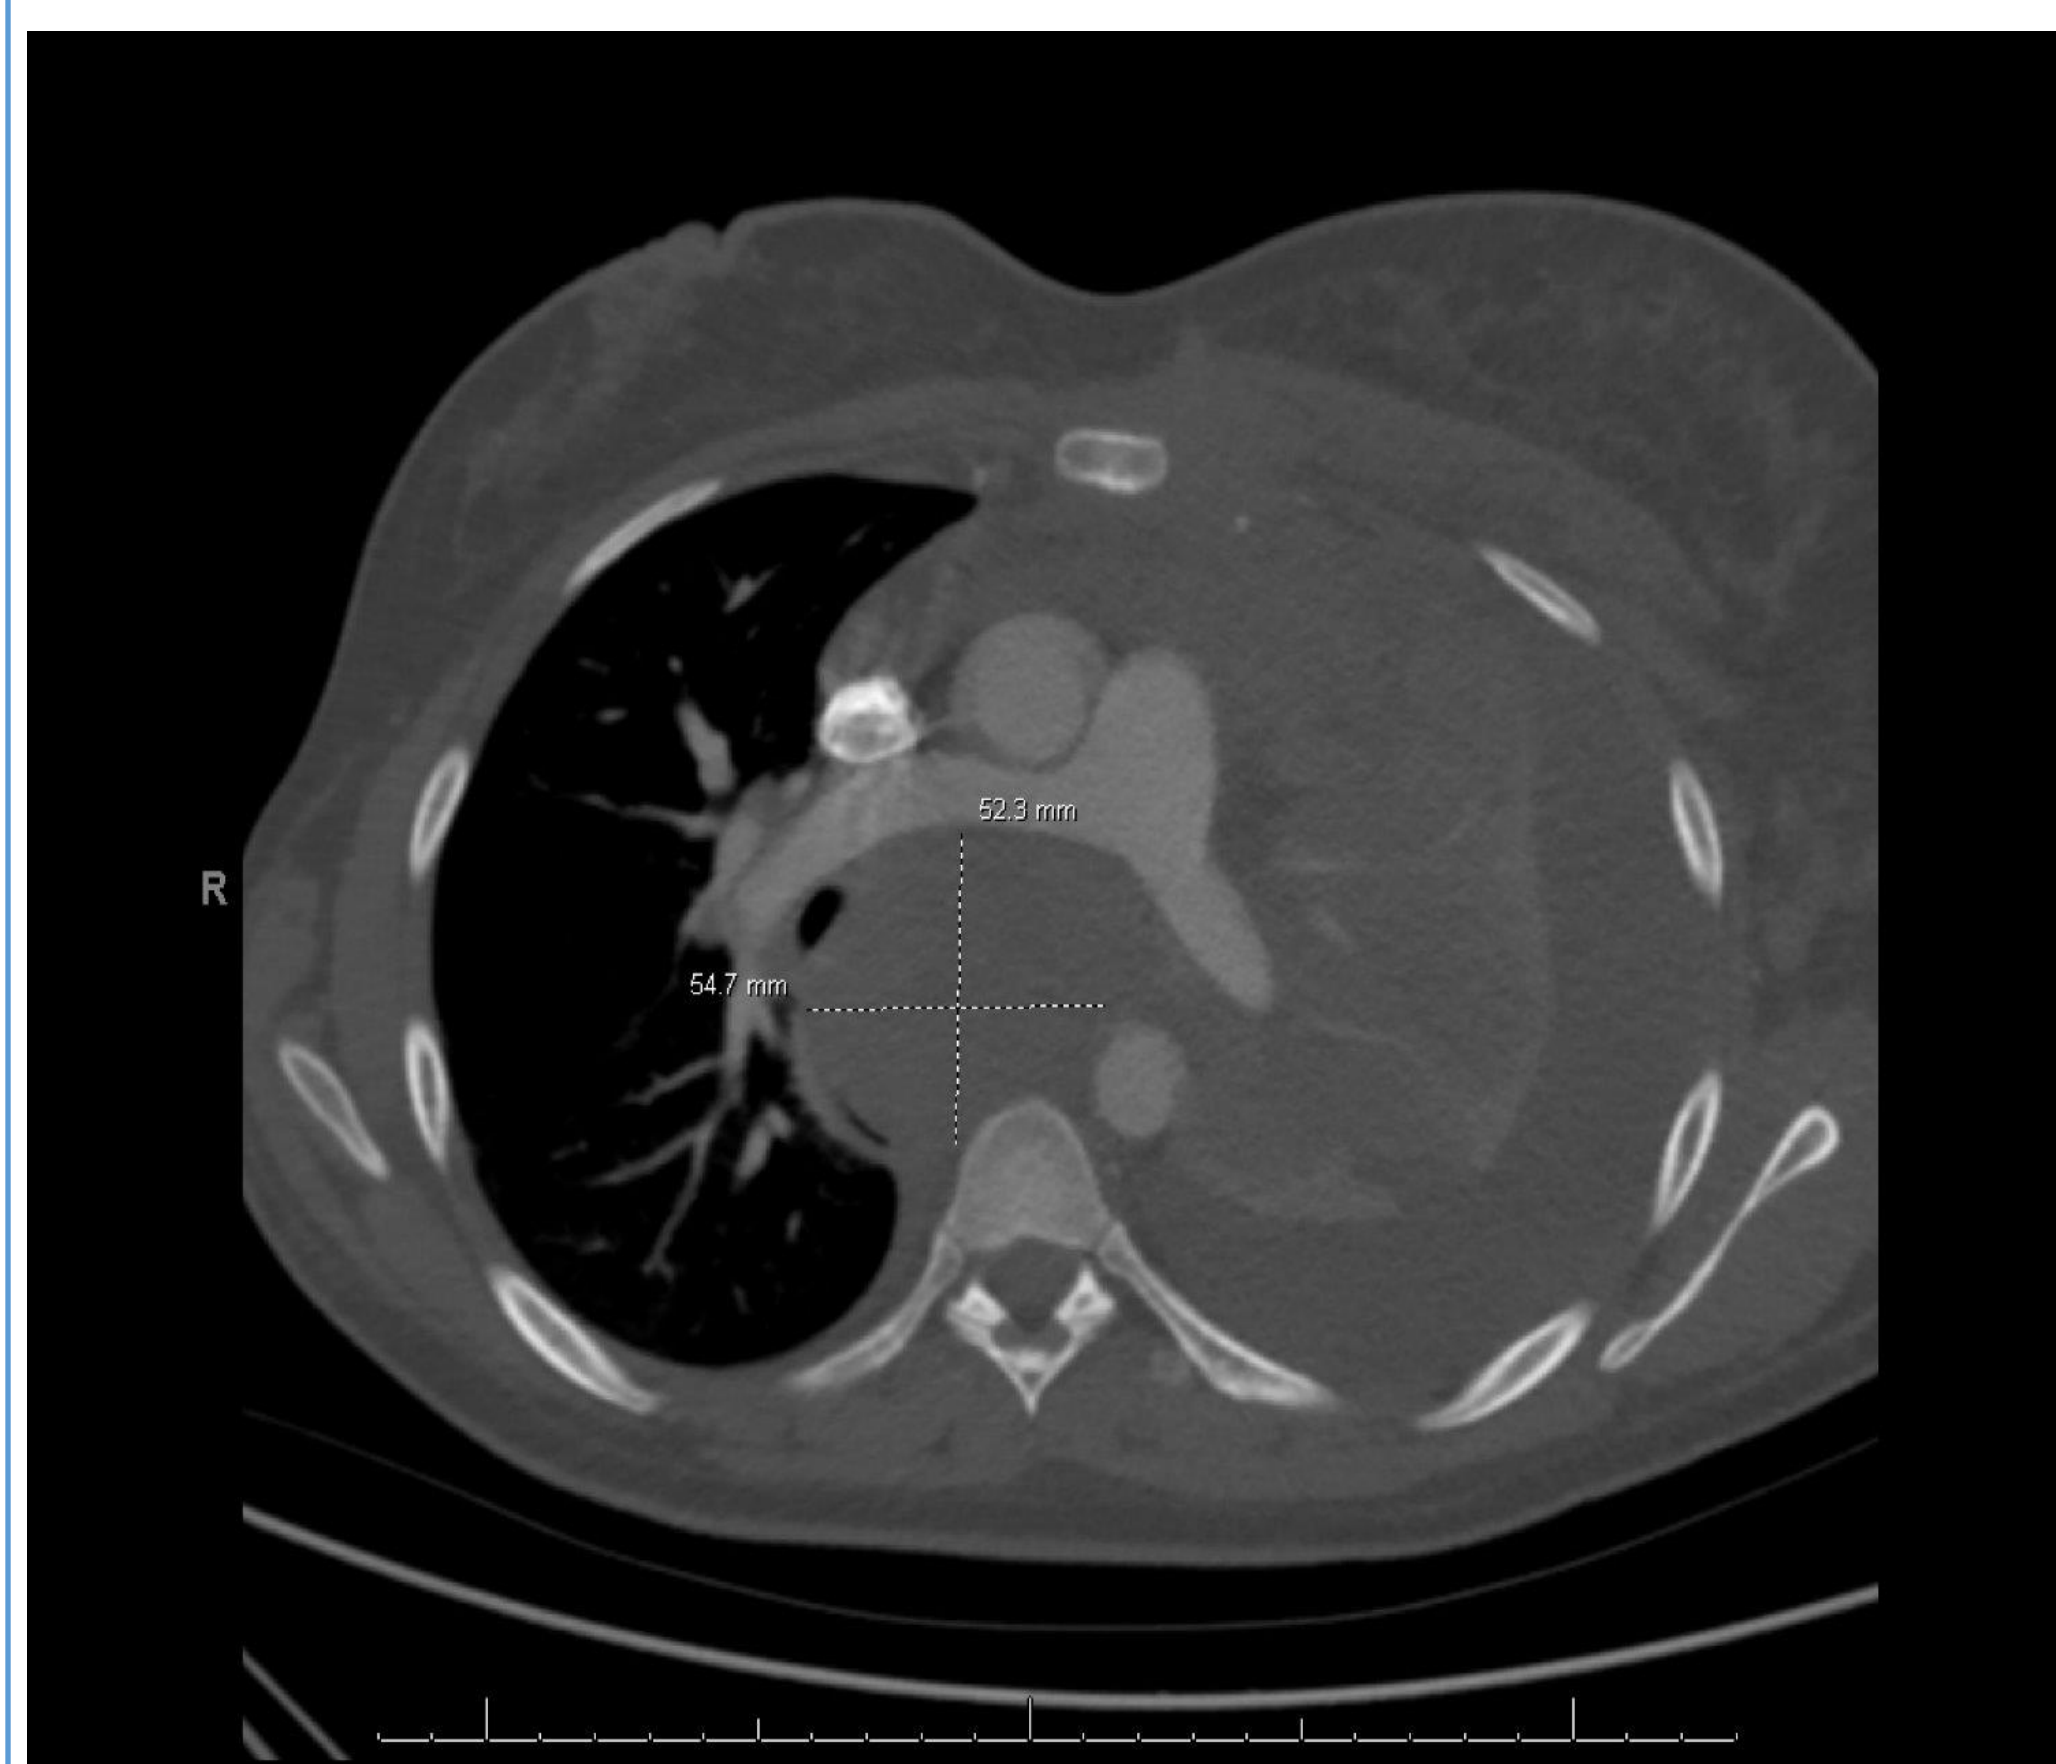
Admission CT Angiogram Chest slice demonstrating marked mediastinal lymphadenopathy in addition to large effusion with complete collapse of left lung.
